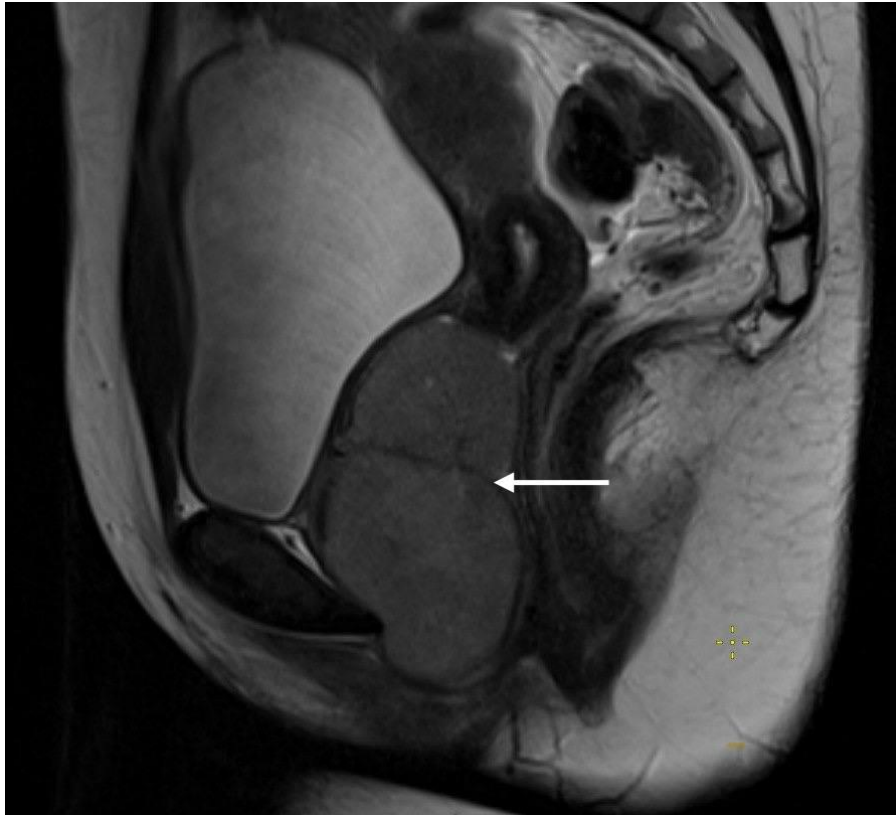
MRI image of a sagittal section of the small pelvis.
